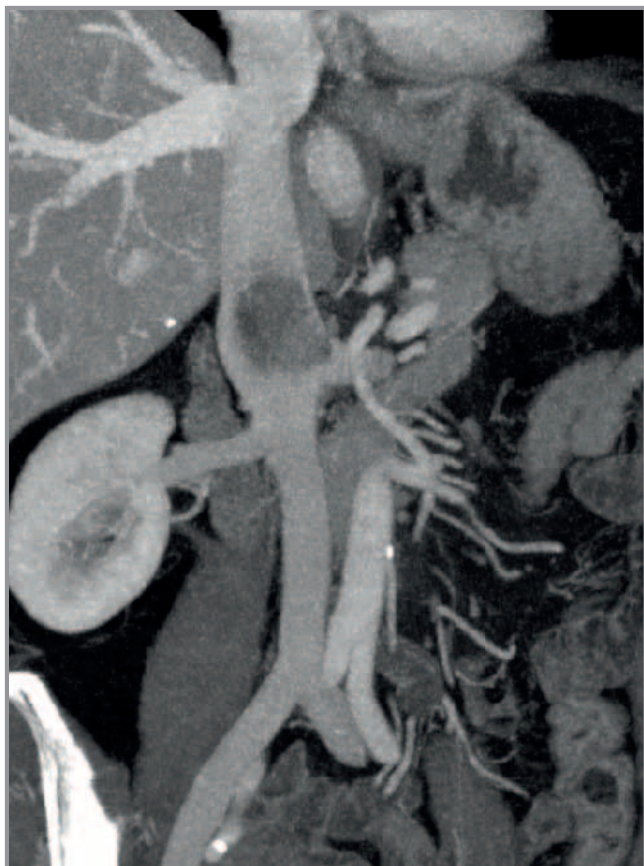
CT image of the growth - height measured in coronal section was 42 mm, volume 15 cm³. The influx of the left and right renal vein is also visible.
